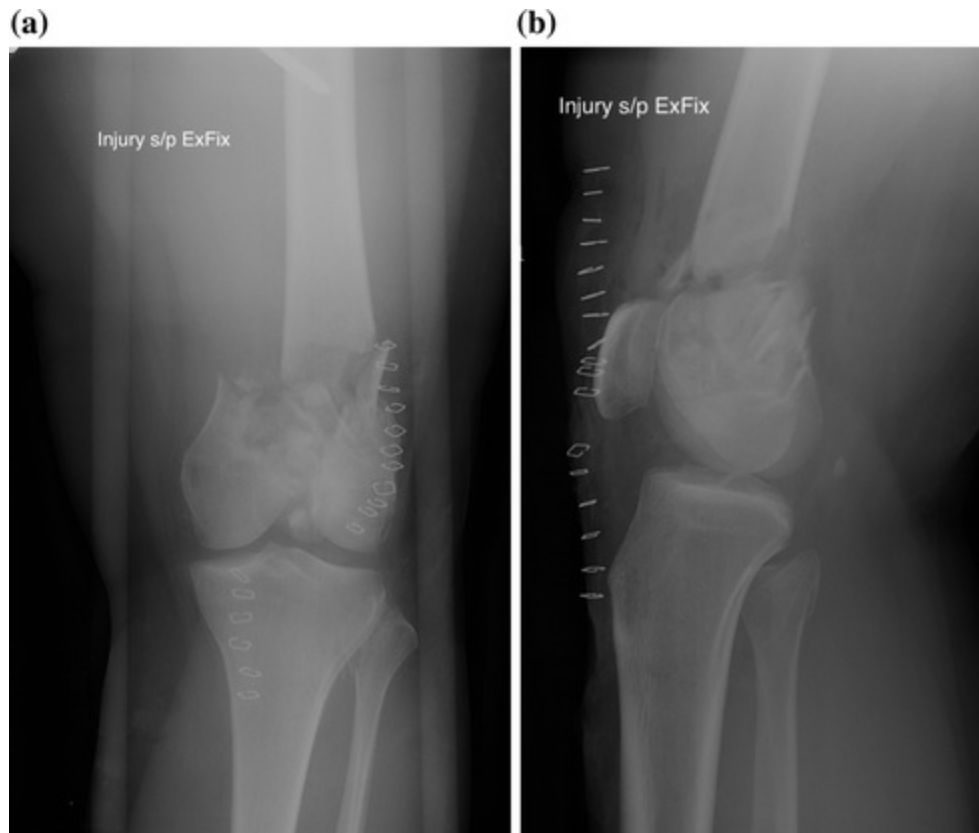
Initial a anteroposterior and b lateral radiographs of the left knee after irrigation and debridement and bridging external fixation
